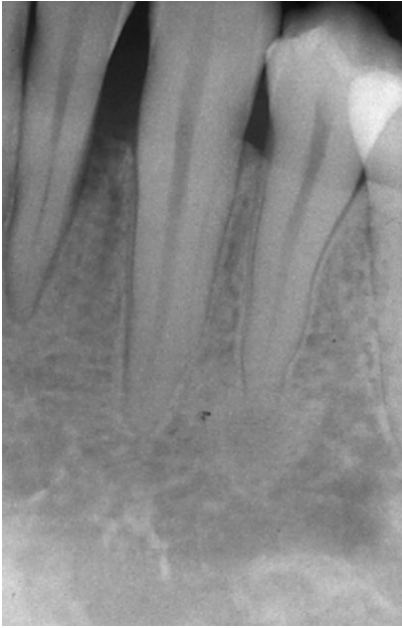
The preoperative X-ray demonstrated the presence of an intrabony defect.
